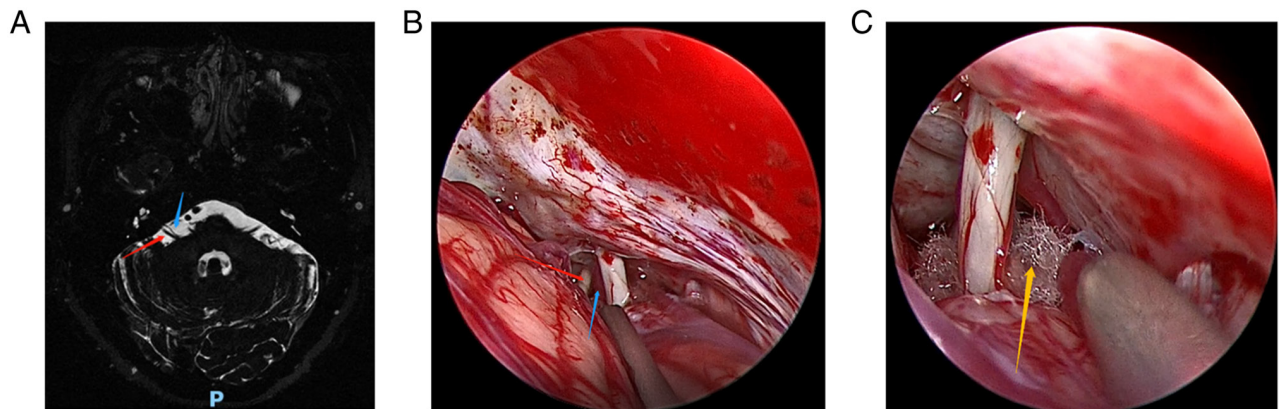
Patient 2. (A) Preoperative head magnetic resonance imaging of the patient. (B) The posterior inferior cerebellar artery and compressed cranial nerves were clearly visible under the endoscopic view. (C) The Teflon pad was placed between the root exit zone of cranial nerve 7 and the posterior inferior cerebellar artery under the endoscopic view. Red arrows indicate the compressed cranial nerve vessels, blue arrows indicate the posterior inferior cerebellar artery and the yellow arrow indicates the Teflon pad.
